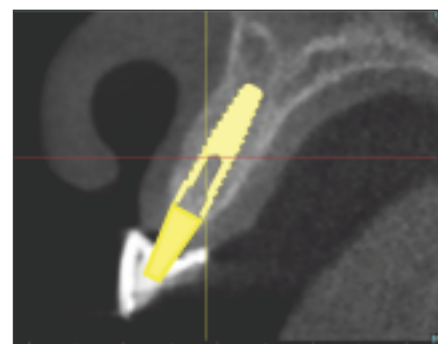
Cross-sectional view of CBCT scan showing relationship of bone to final prosthetic position.
